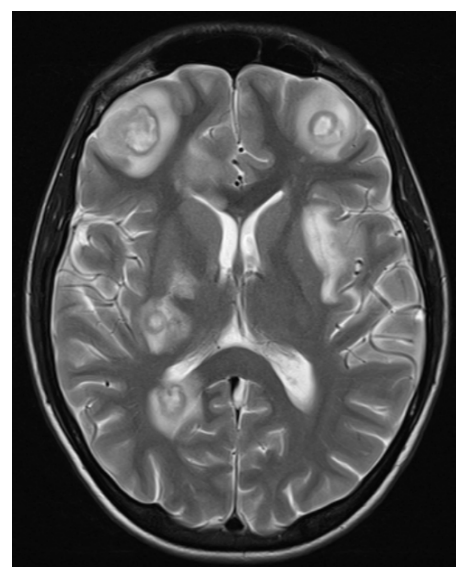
Magnetic resonance imaging of the brain demonstrating multiple ring-enhancing lesions with significant vasogenic oedema, consistent with pyogenic abscesses, predominantly distributed throughout the supratentorium.
